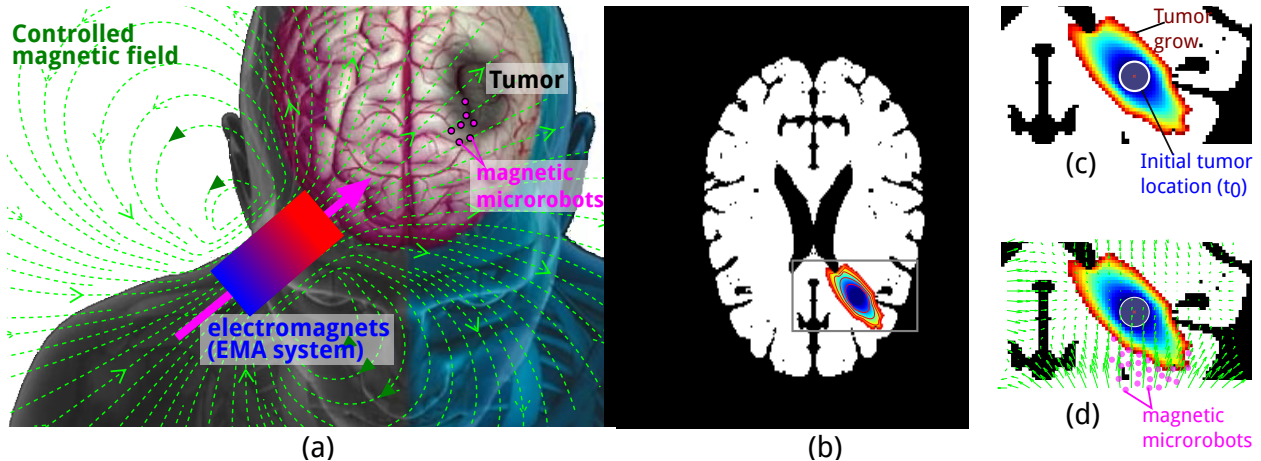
(a) Controlled magnetic microrobot to deliver drugs in brain tumors: (b) tumor is located with medical imaging (e.g. from MRI); (c) without treatment, the tumor is growing that can be predicted thanks to mathematical models; and (d) the control of magnetic field allows targeting the brain tumor.
